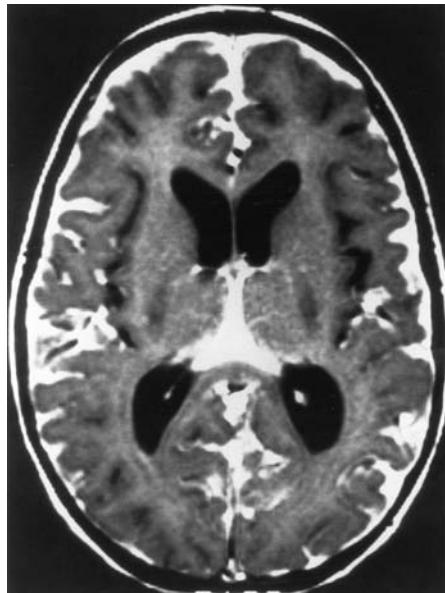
Post-contrast T1-weighted MRI of diffuse melanocytosis, showing contrast enhancement of the infiltrated meninges.
